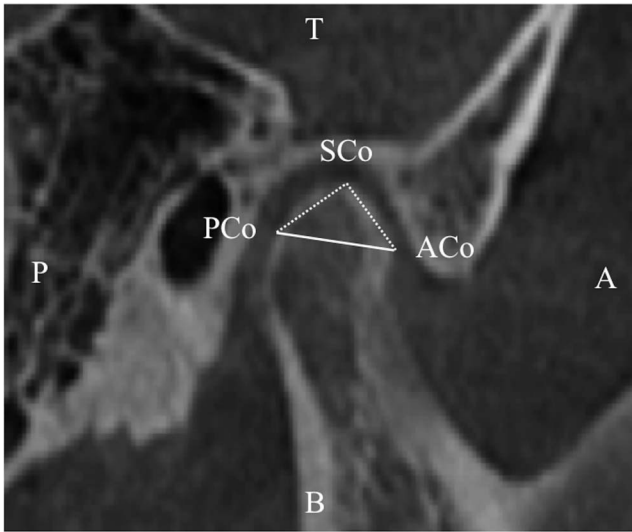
The condylar length on the sagittal cone-beam computed tomography image. A = anterior direction, P = posterior direction, T = top direction, B = bottom direction, SCo = the most superior mandibular condyle point, ACo = anterior mandibular condyle point, and PCo = posterior mandibular condyle point.
